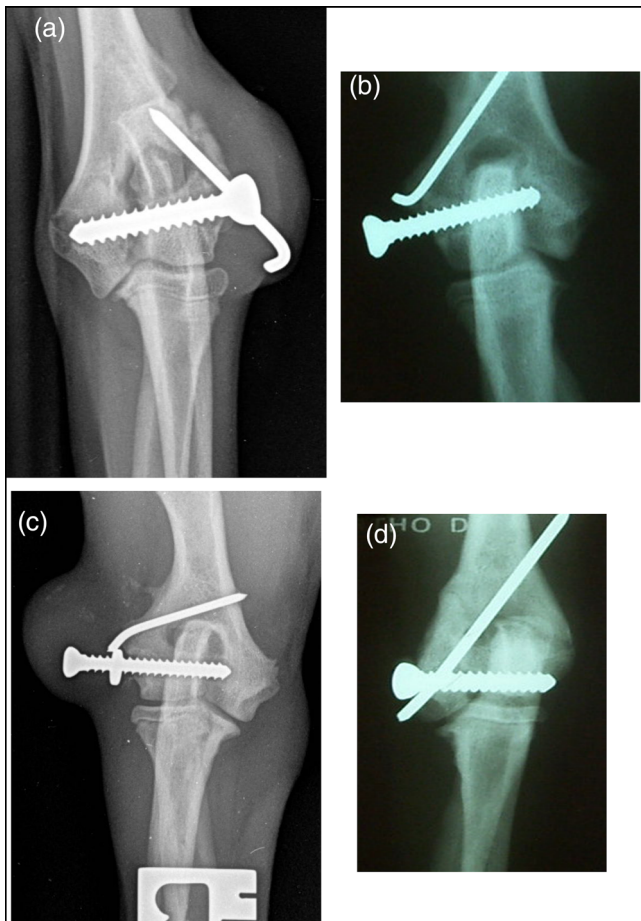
(a) Craniocaudal radiograph of the left elbow of a 17-week-old Golden Doodle taken 3 weeks after treatment. The 2.0 mm K-wire has migrated and the bone screw (positional) backed out. Fracture reduction has been retained and revision involved re-tightening of the bone screw and placement of a 2.4 mm pin. (b) Craniocaudal radiograph of the right elbow of an 18-week-old Jack Russell Terrier taken 6 weeks after treatment. The bone screw has backed out and was removed through a stab incision at the time of radiography. (c) Craniocaudal radiograph of the right elbow of a 22-week-old French Bulldog taken 8 weeks after treatment. The 3.5 mm bone screw has backed out and was replaced with a 4.5 mm bone screw because a faint fracture line is still evident in the condyle distal to the bone screw raising concern over a condylar fissure, especially given the breed involved. (d) Craniocaudal radiograph of the left elbow of a 19-week-old Pug taken 6 weeks after treatment. A moderate lameness was present, which resolved within 4 weeks of implant removal
